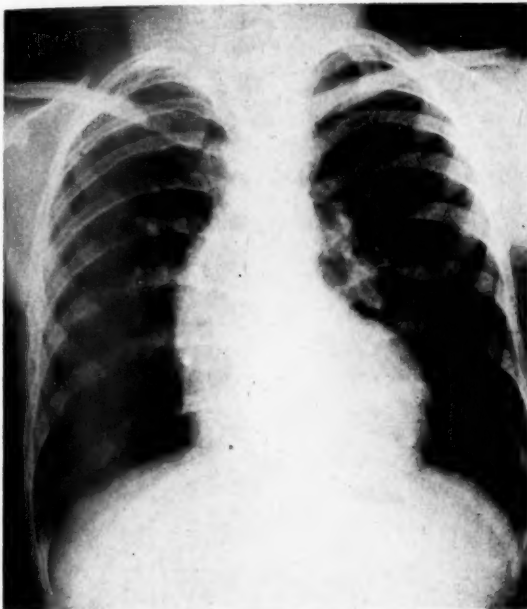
Chest roentgenogram taken June 26, 1950, seven years before bacterial endocarditis and two months before repair of coarctation of the aorta. Note rib notching only on the right side, enlarged ascending aorta and prominent left ventricle.
